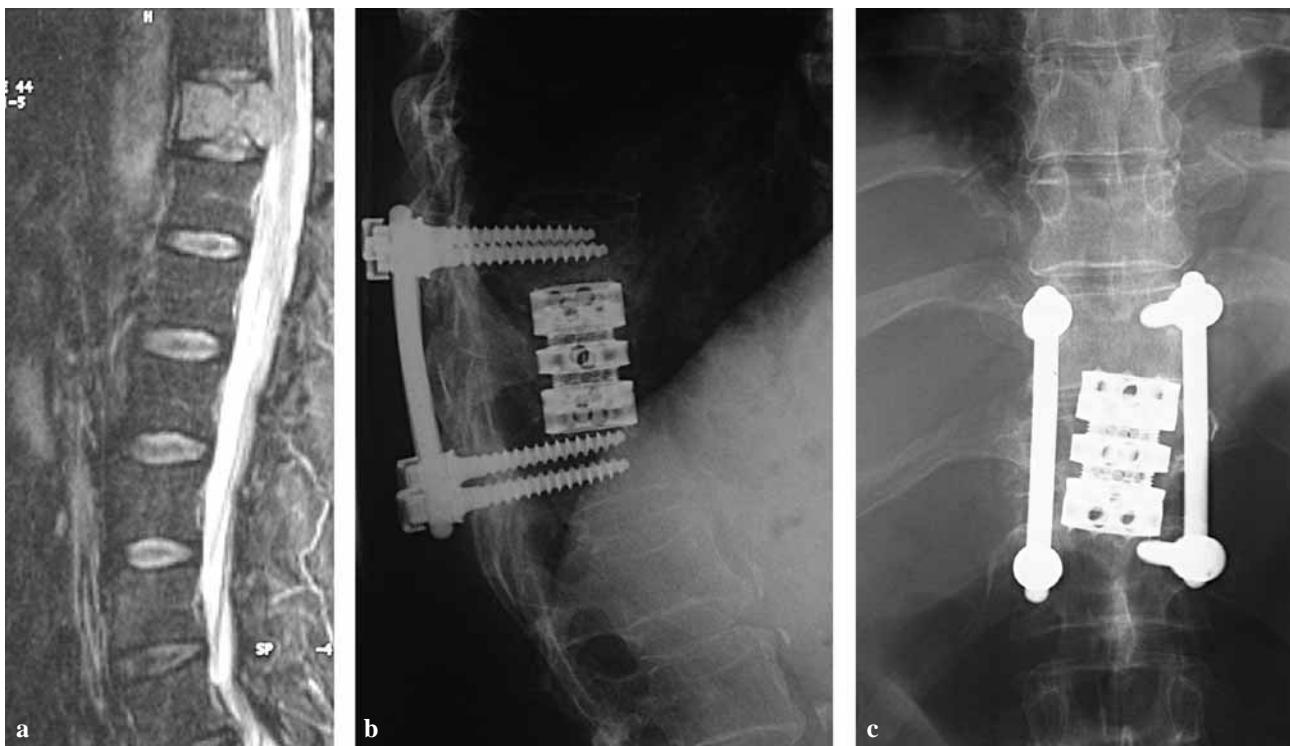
a) Sagittal MRI image shows a metastatic lesion at T11 with spinal chord compression ; b) + c) Dorsal instrumentation and decompression in combination with vertebral body replacement.
